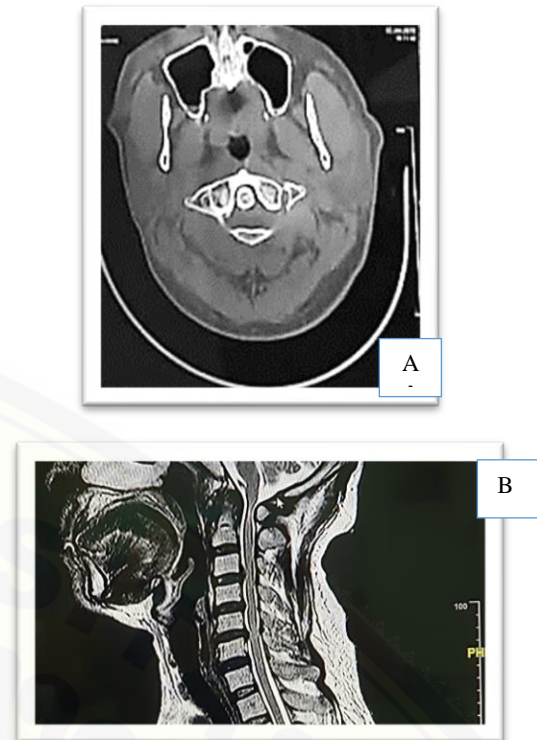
MRI of the cervical spine in A. Axial plane and B. Sagittal plane show mass of retro odontoid tumor
